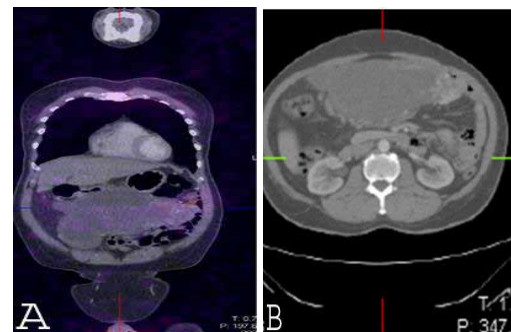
Abdominopelvic CT scan for Gastric GIST Tumor 33 cm in Diameter A. Coronal Section B. Axial Section (Huge intrabdominal swelling occupied the abdomen and pelvis).
